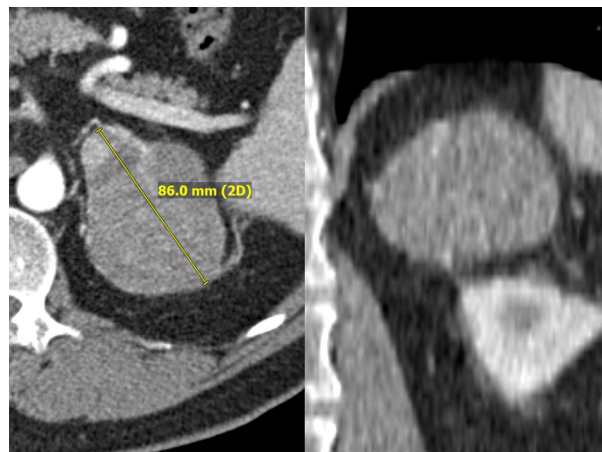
Axial and coronal image from pre-procedure CT scan demonstrating heterogeneously enhancing left adrenal RCC metastasis, measuring 8.6 cm. CT, computed tomography; RCC, renal cell carcinoma.
